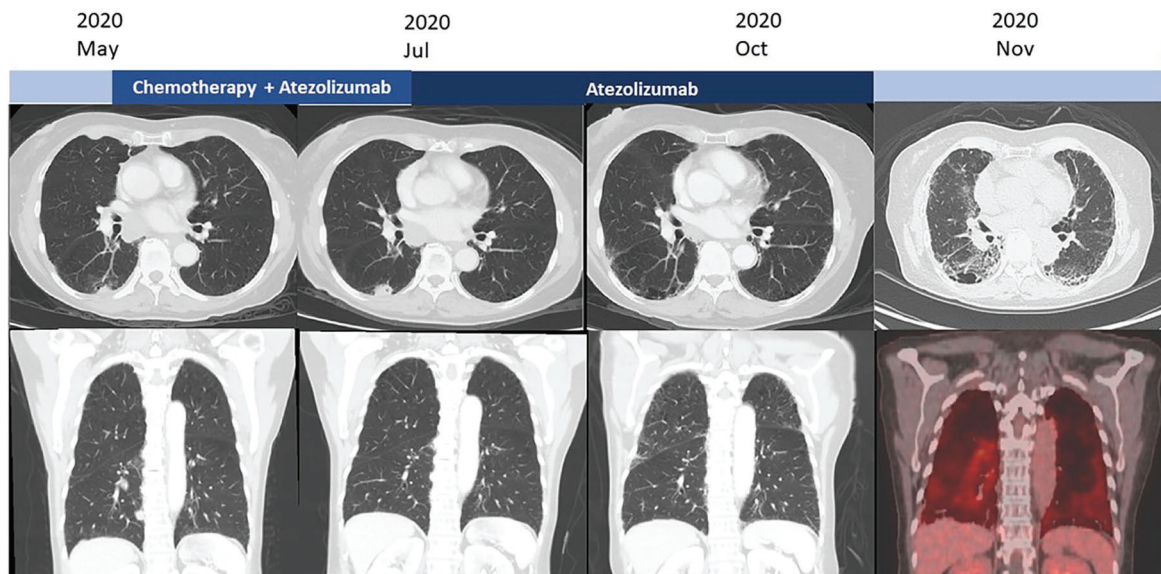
Chest computed tomography (CT) images.
